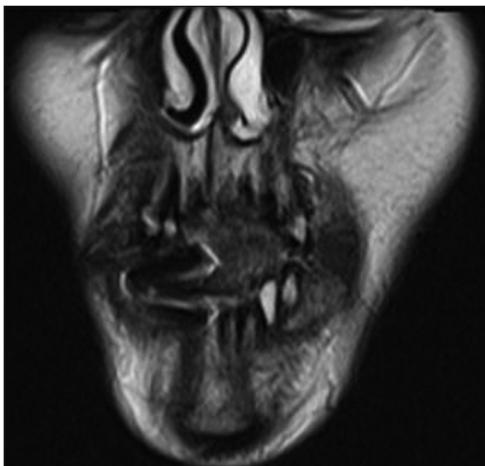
MRI (coronal view)
